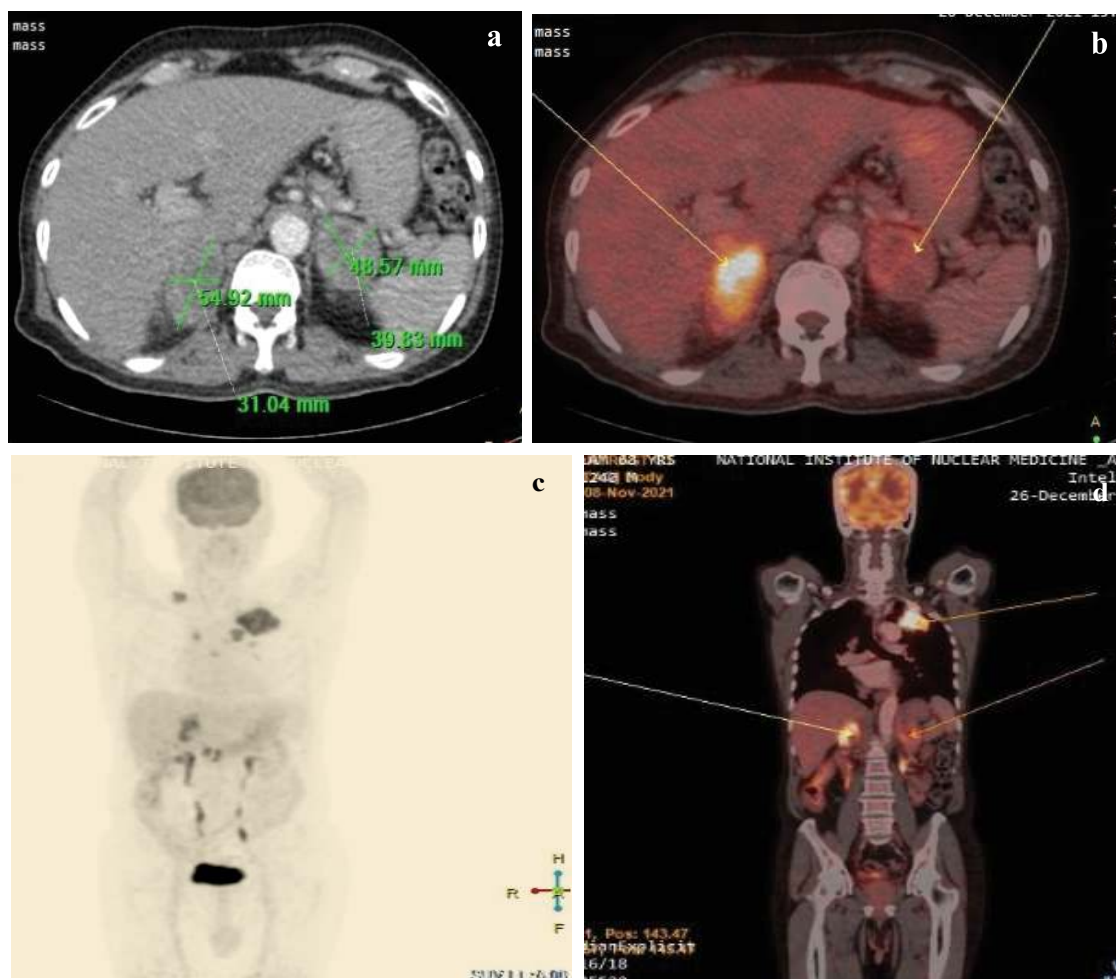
From left to right - upper row demonstrating a) transaxial contrast enhanced CT and b) fused ¹⁸F-FDG PET-CT images of upper abdomen showing large, hypermetabolic, soft tissue density masses in both adrenal glands (arrowed) suggestive of bilateral adrenal metastases; lower row demonstrates c) whole body maximum intensity projection image of PET scan and d) fused coronal ¹⁸F-FDG PET-CT image with visible lung and adrenal lesions (arrows).
